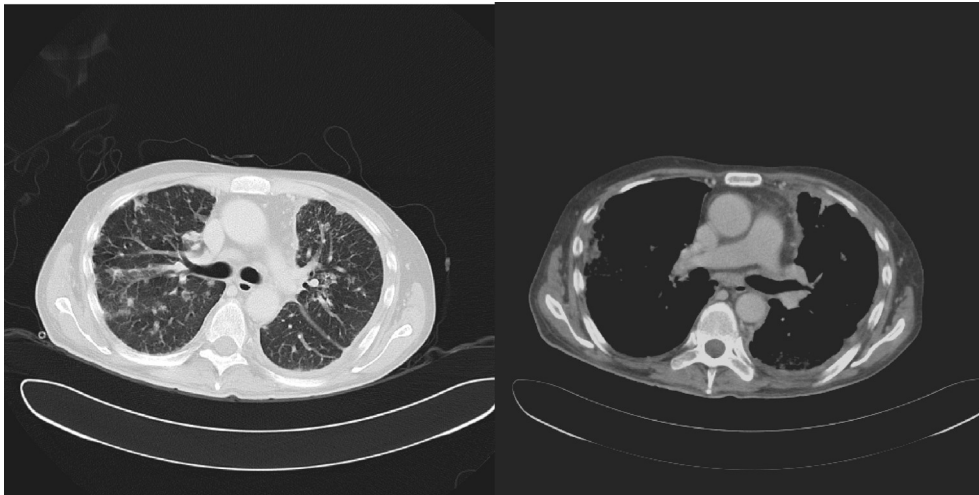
CT scan after drainage of the left pleural effusion showing multiple pulmonary nodules and diffuse pleural thickening in the left lung extending to the mediastinum pleura.
